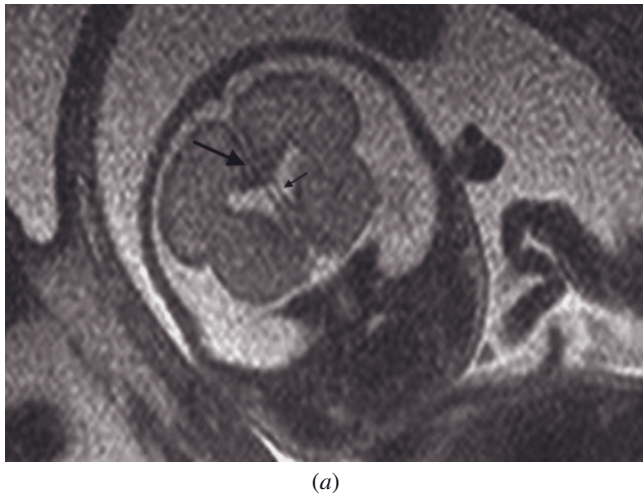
Normal corpus callosum. Coronal (a) and sagittal (b) T2-weighted SS-ETSE images of the fetal head demonstrate a normal corpus callosum at 25 weeks of gestation. The normal corpus callosum is seen as a subtle band of T2 hypointensity (large arrows, a, b). Note the normal cavum septum pellucidum (small arrow, a).
